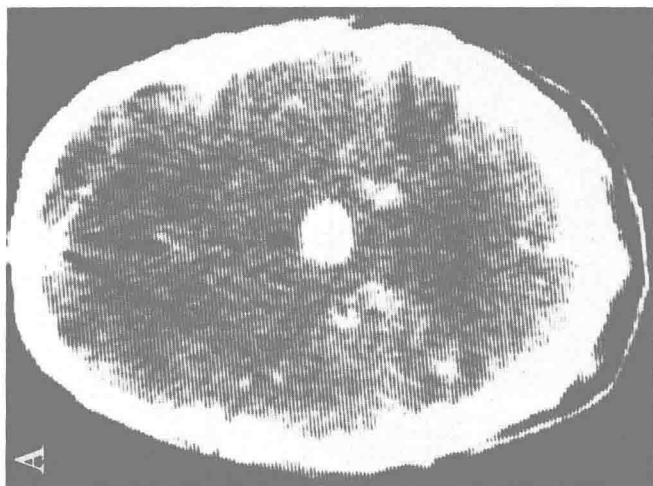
(a.) Contrast enhanced CT scan demonstrates a high-density lesion adjacent to the third ventricle. (b.) Left vertebral angiogram demonstrates an aneurysm originating from the apex of the basilar artery. The terminal branches of the posterior cerebral artery terminate in an occipital lobe arteriovenous malformation. Arteriovenous malformations are associated with cerebral aneurysms in 1.5 percent of patients. (From Wolpert SM: *Neuroradiology of the Posterior Fossa*, in *Surgery of the Posterior Fossa*. New York, Raven Press, 1979.)
